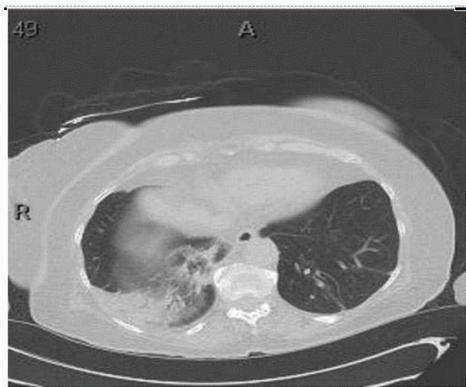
CT of the chest : right lower lobe consolidation.
